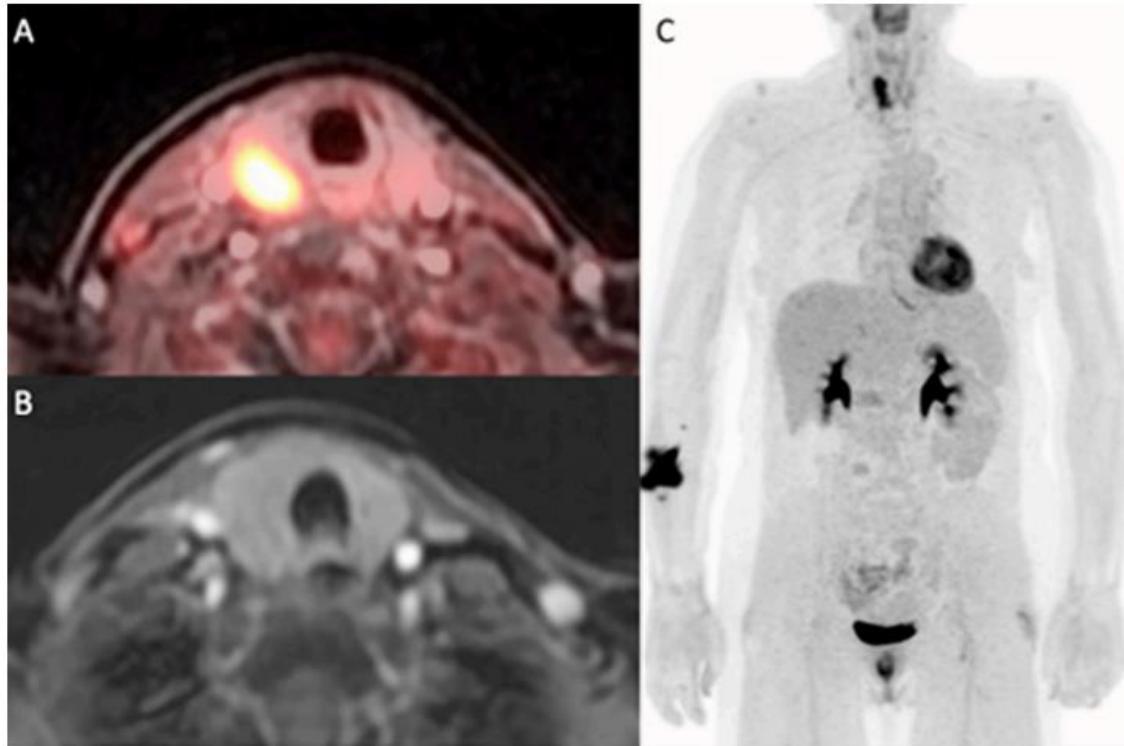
Example of patient classified as Likert 3. The F-18 FDG PET/MRI fusion image (A) and PET 3D image (C) show an increased FDG uptake in the right lobe of thyroid gland. No lesion of thyroid gland was visible on LAVA WATER image (B). Finally, subacute thyroiditis was diagnosed.
